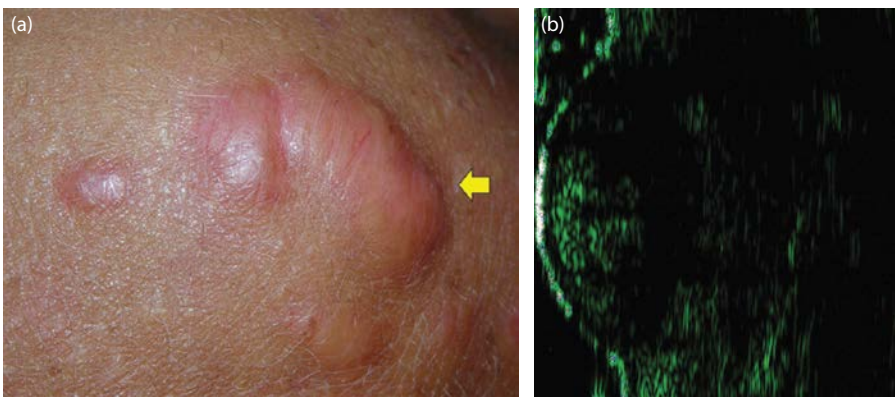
Keloidal scar: (a) clinical and (b) ultrasound appearance.
